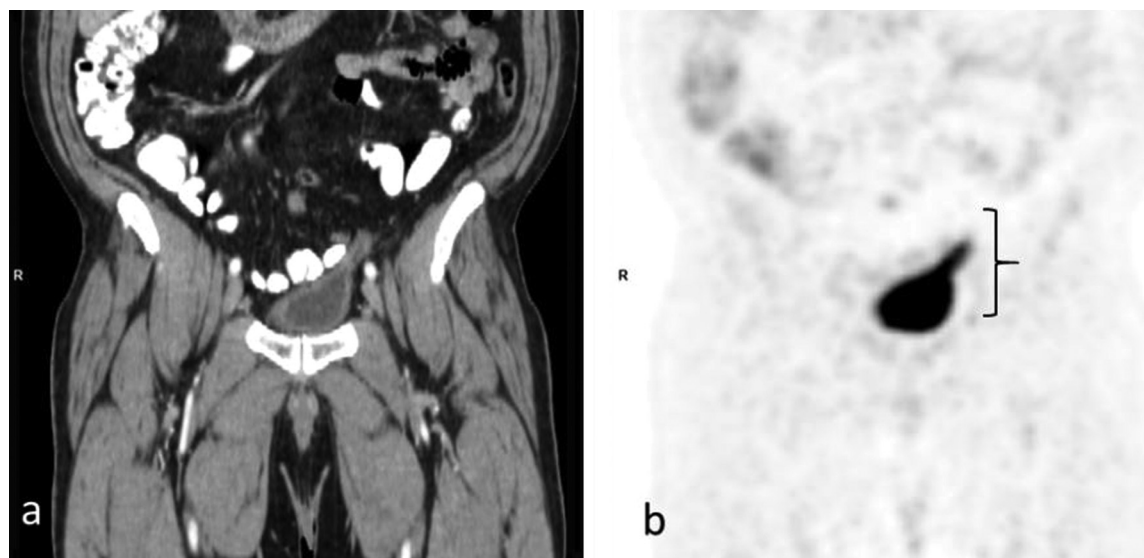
Coronal view of ¹⁸F-fluorodeoxyglucose computed tomography (A) and positron emission tomography (B) demonstrating homogeneous concentration of the radiotracer in the bladder and in the left distal part of the reimplanted ureter (*black brace*). No evidence of stricture or dilatation of the ureter, and no pathological focal enhancement noticed on the computed tomography.
